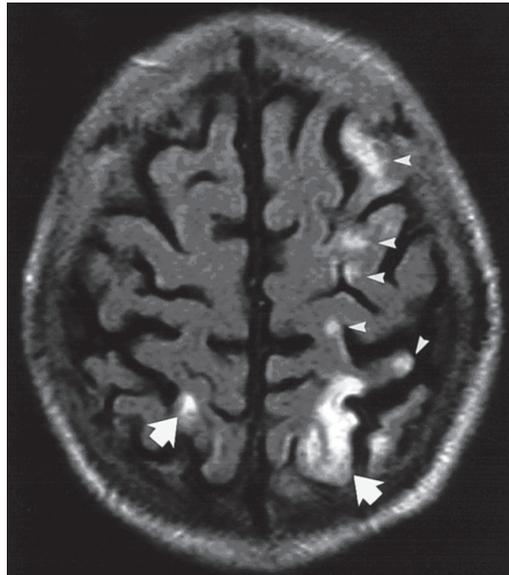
Transverse MR image after left-sided carotid angioplasty and stenting (FLAIR image, TR 6500, TE 120 ms, inversion delay 2000 ms) demonstrates new and enlargement of preexisting hyperintense lesions on the side of stenting
